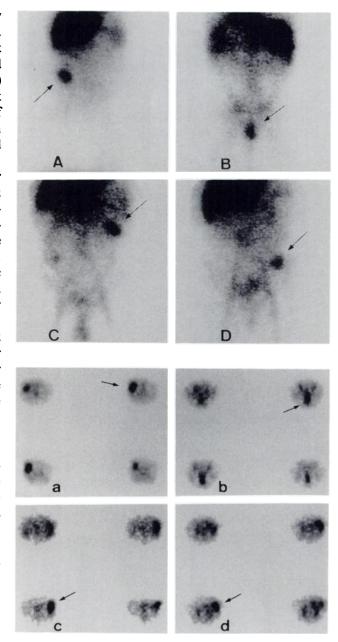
Planar and transaxial SPECT slices of four patients. One planar image (A-D) and a set of 4 slices (a-d) are displayed for each patient. The patients depicted in A/a, B/b, C/c and D/d are numbered 4, 9, 13 and 14 in Table 1, respectively. Planar scintigraphies include the whole abdomen in either anterior (A, C, D) or posterior view (B). The transaxial slices (2 pixels) are displayed from top to bottom, with a 2-pixel space between the slices which are shown. The slices were selected to pass through the upper, center and lower part of each tumor. Arrows point to the tumors.
